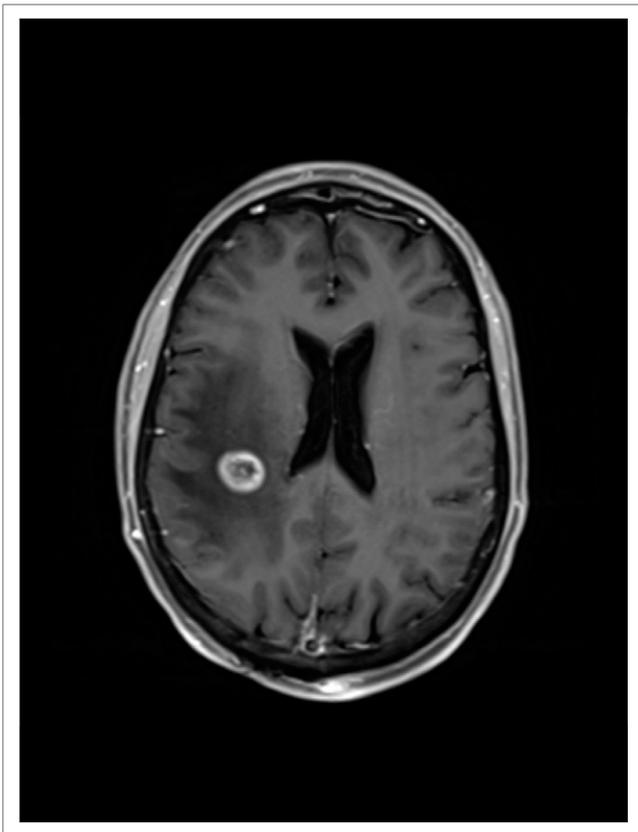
Axial T1-weighted fat-saturation post-gadolinium MR image highlighting enhancing mass.
